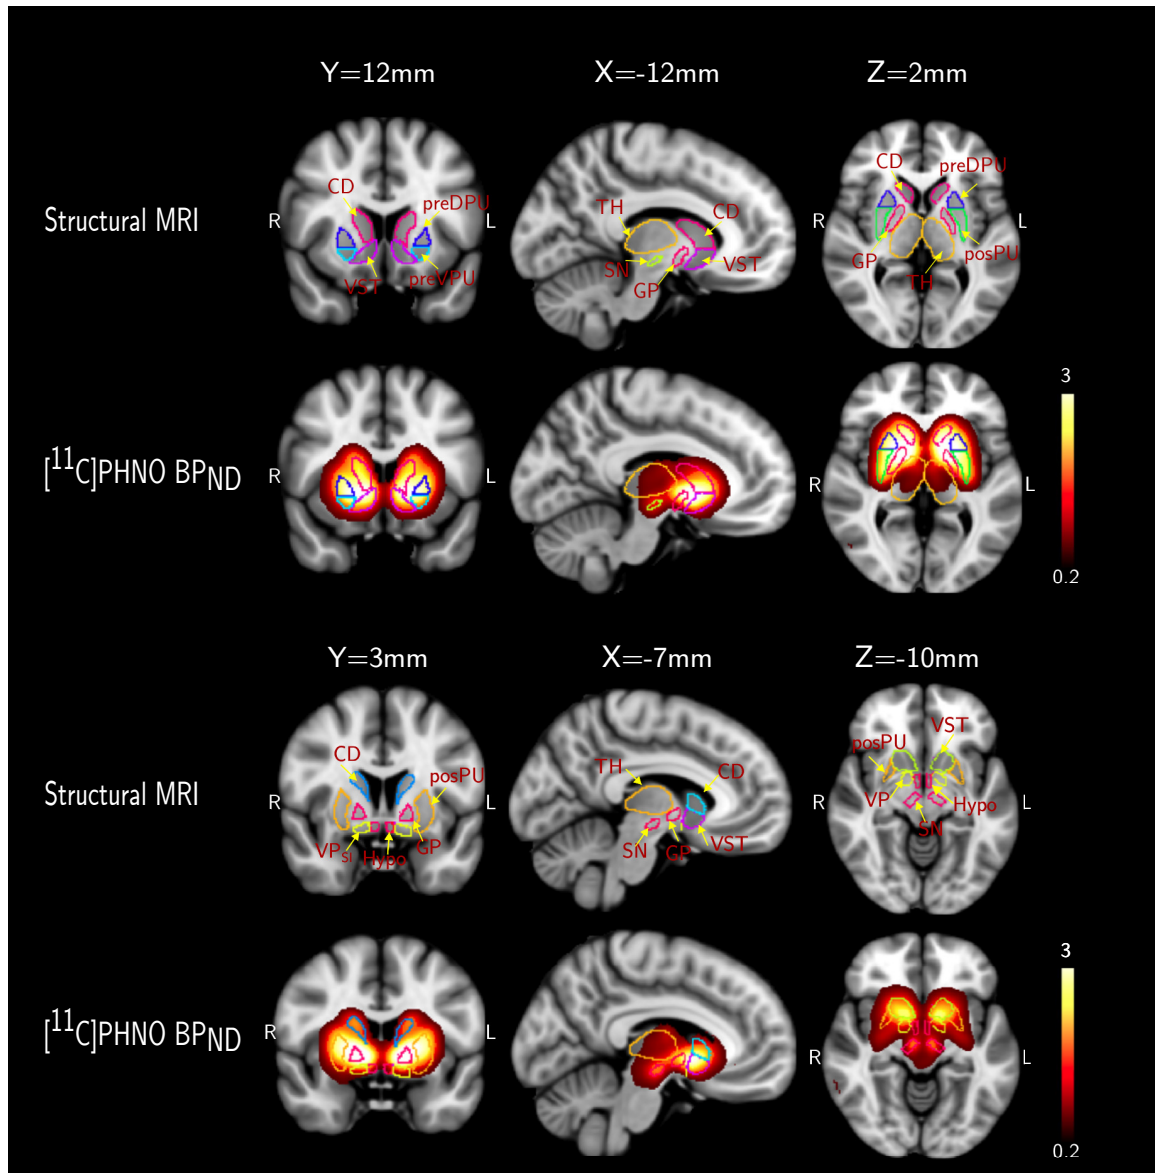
ROIs overlaid on $[^{11}\text{C}]\text{PHNO BP}_{\text{ND}}$ parametric images and onto the T1-weighted MNI template in the pre-commissural (first 2 rows) and the post-commissural striatum (bottom rows). R=right; L=left;
